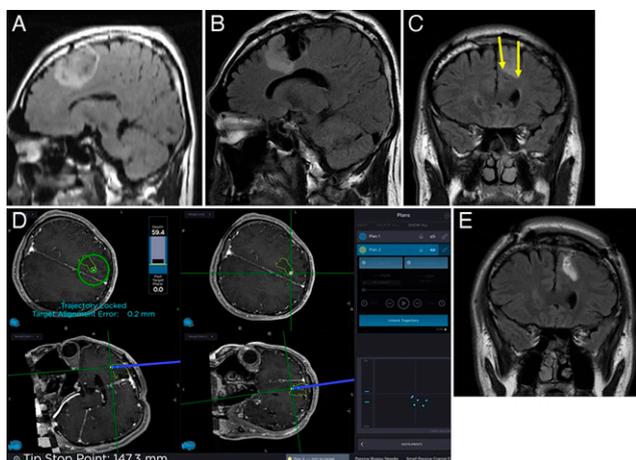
MRI revealed an intraaxial tumor in the left frontal lobe. A: The lesion presented as high-intensity signal on fluid-attenuated inversion recovery (FLAIR) imaging. B: After 2 years, the tumor recurred in front of the extraction cavity (FLAIR imaging). C: Fence-post tube placement was planned for the anterior end of the recurrent tumor and the deepest part from the center of the tumor (arrows). D: The fence-post tubes were inserted using the robot-guided frameless stereotactic technique followed by neuronavigation before the dural incision. E: Postoperative MRI showed gross total resection (FLAIR imaging).
